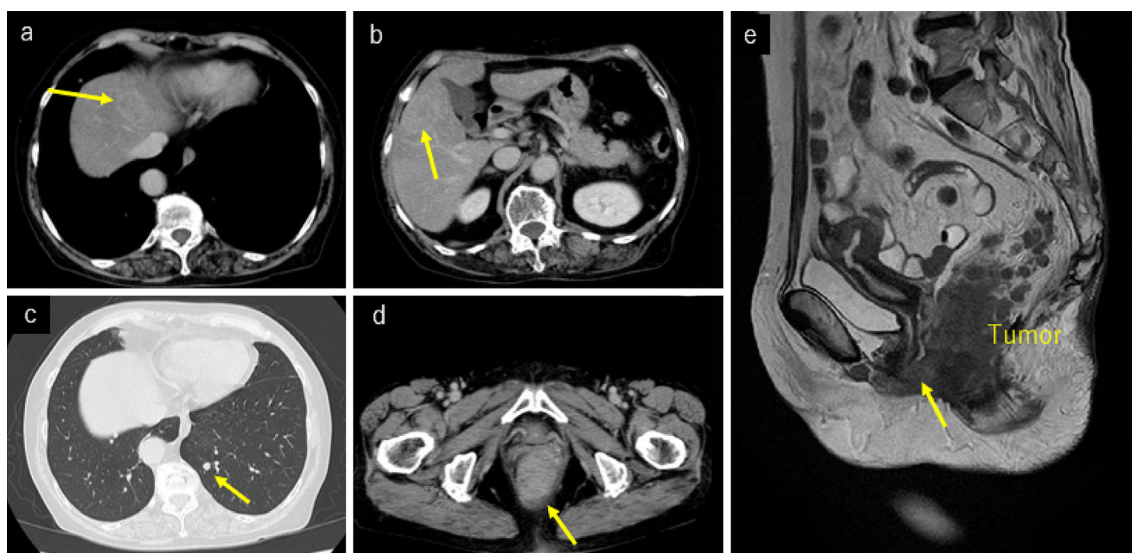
Contrast-enhanced CT showed hepatic (a, b) and pulmonary metastatic lesions (c), and the primary lesion appeared as a mass with contrast enhancement (d). MRI showed invasion of the primary lesion into the vaginal wall (e).
